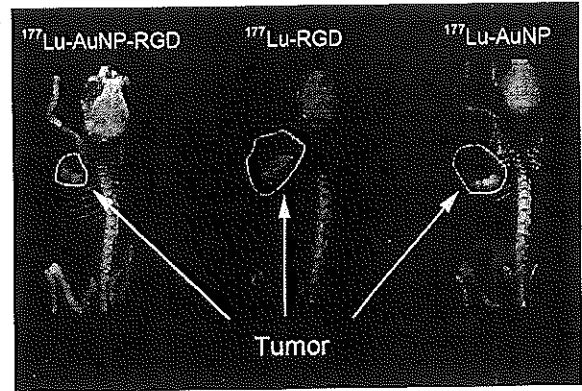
micro-SPECT/CT images of ¹⁷⁷Lu-AuNP-RGD, ¹⁷⁷Lu-AuNP and ¹⁷⁷Lu-RGD at 24 h after the last injection (at 22 days of treatment). The tumor areas in which no radioactivity is observed is necrotic tissue. Extensive necrotic foci are present in advanced stages of glioblastomas and in less-advanced neoplasms necrosis occurs sparsely. ¹⁷⁷Lu-AuNP-RGD tumor uptake is more homogeneous indicating less necrotic tissue.
